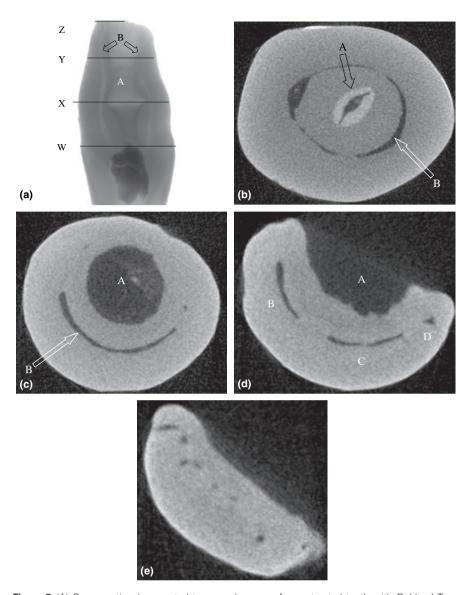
(A) Cross-sectional computed tomography scan of an extracted tooth with Oehlers' Type IIIB. Note the complex internal morphology of the invagination (A) and root canal system (B). (b) Axial slice of the tooth at point W. At this level the invagination is still lined by enamel (A) with the pulp almost obliterated (B). (c) Axial slice of the tooth at point X. The enamel lining has disappeared with the invagination now having a larger lumen (A) There are still some pulp remnants (B). (d) Axial slice of the tooth at point Y. The invagination has now merged with the periodontal ligament (A). Note that the pulp is now present in three different areas (B, C and D). (e) Axial slice of the tooth at point Z. The apex showing eight separate apical foramina.
